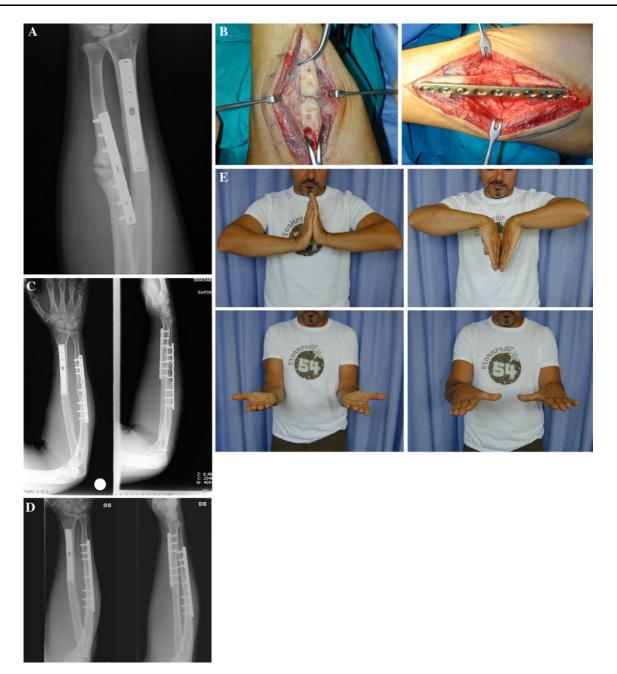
a Hypertrophic non-union of the ulnar shaft treated with plate and screws. b Intraoperative view of the modified Nicoll's technique with the trapezoidal-shaped bone graft. c X-ray view after 1 month.
